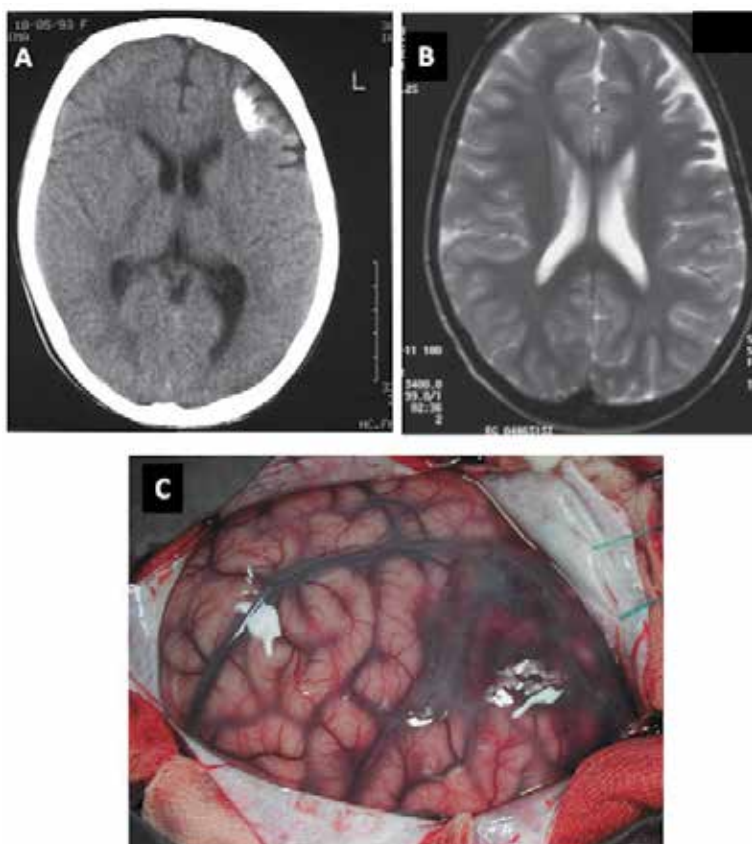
Frontal lobe lesion of Sturge-Weber syndrome. A. Computerized tomography showing a coarse calcification. B. MRI with frontal focal atrophy. C: Intra-operative classical leptomenigeal angiomatosis.
